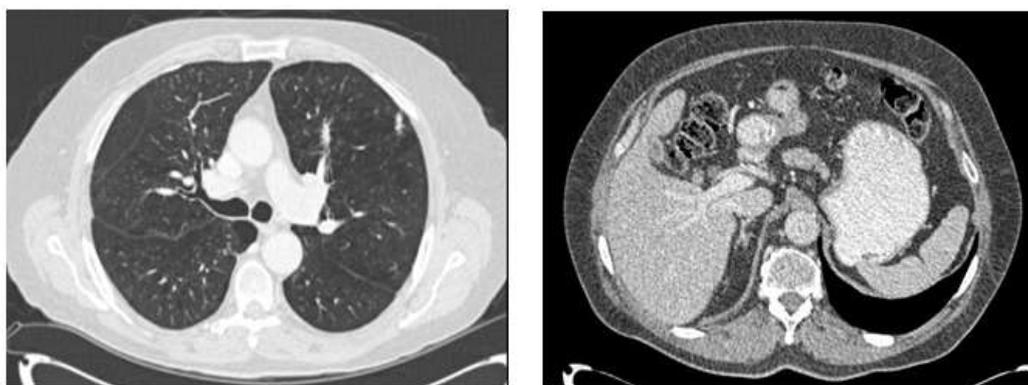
Response of metastatic disease to chemotherapy. Axial views of CT chest (left) and abdomen (right) showing significant improvement in metastatic disease.
